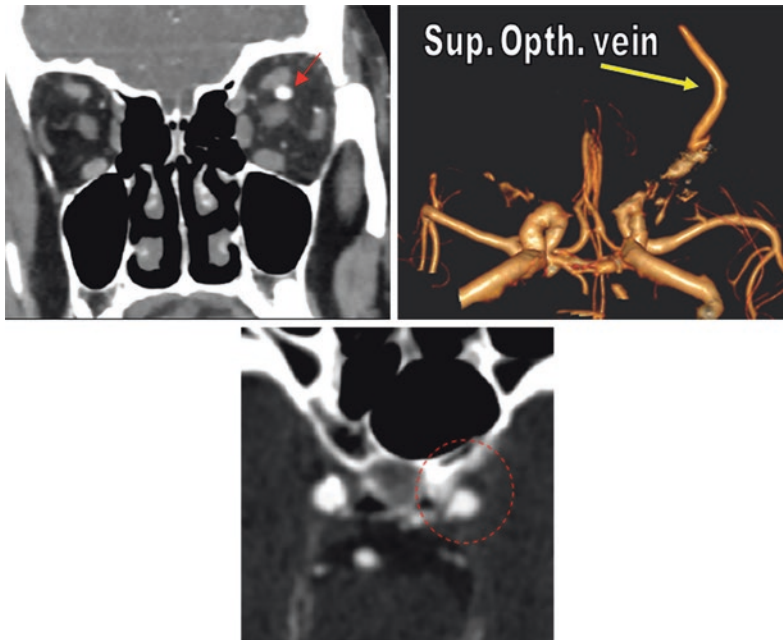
CTA images idiopathic carotid cavernous fistula a 45 years old female patient. a, b Coronal CTA through the orbit and 3D reconstructed images demonstrate dilation of the left superior ophthalmic vein along its whole course with early enhancement in the arterial phase images (arrows). c Axial CTA image at the level of the cavernous sinus demonstrates early arterial enhancement of the cavernous sinus (circle). Associated engorgement of the left extraocular muscles compared to the normal right side
